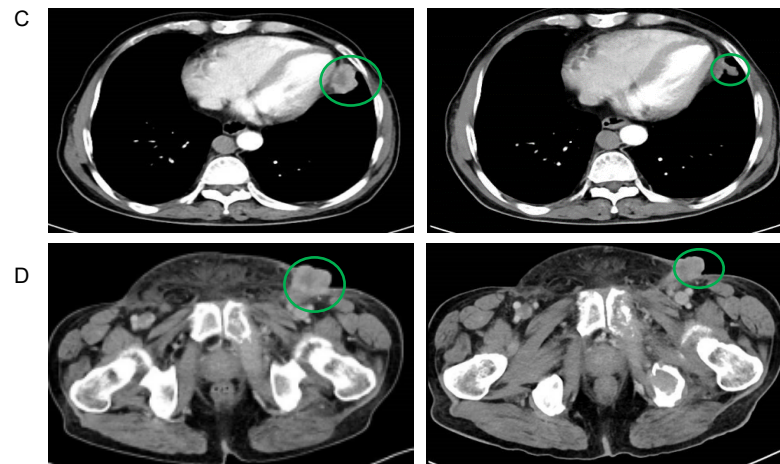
CT scans were conducted before (2022-01-10) and after (2022-02-07) the second cycle of PRaG 1.0 therapy.
